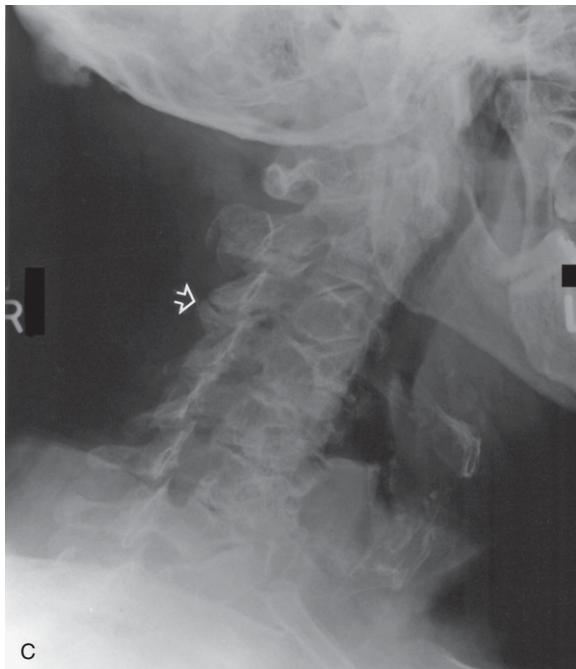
Cont'd (C) Oblique cervical spine plain X-ray images showing the widespread osteoarthritic changes involving the intervertebral joints (white arrows), the zygapophysial joints (open arrow), and the uncovertebral joints with osteophytic encroachment upon some intervertebral foraminae (arrowhead).
